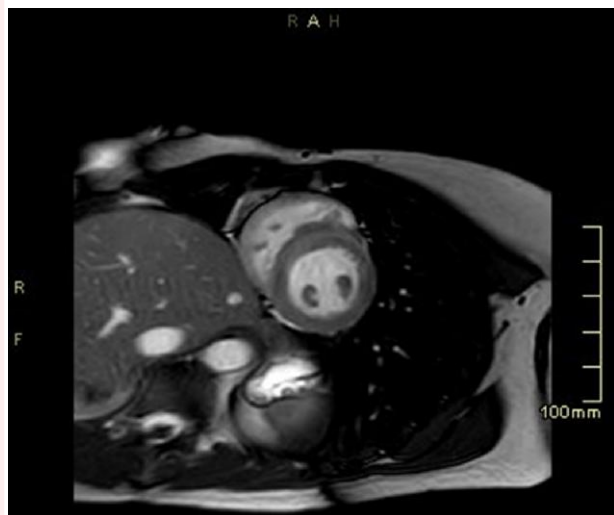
The image of ‘dark-paps’ on cardiac MRI. This is a hypo-intense aspect of the papillary muscles that is being recognized as an independent predictor associated with an increased risk of ventricular arrhythmia.³
